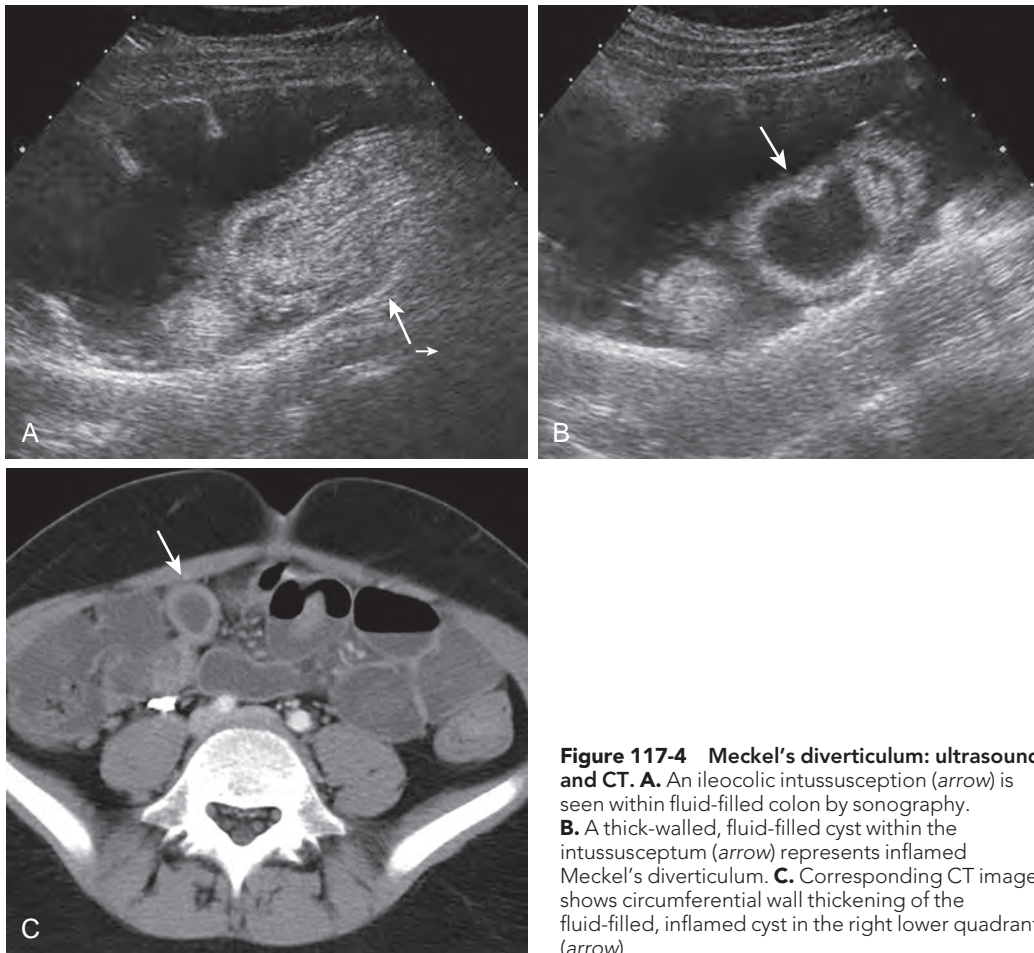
Meckel's diverticulum: ultrasound and CT. A. An ileocolic intussusception (arrow) is seen within fluid-filled colon by sonography. B. A thick-walled, fluid-filled cyst within the intussusceptum (arrow) represents inflamed Meckel's diverticulum. C. Corresponding CT image shows circumferential wall thickening of the fluid-filled, inflamed cyst in the right lower quadrant (arrow).
